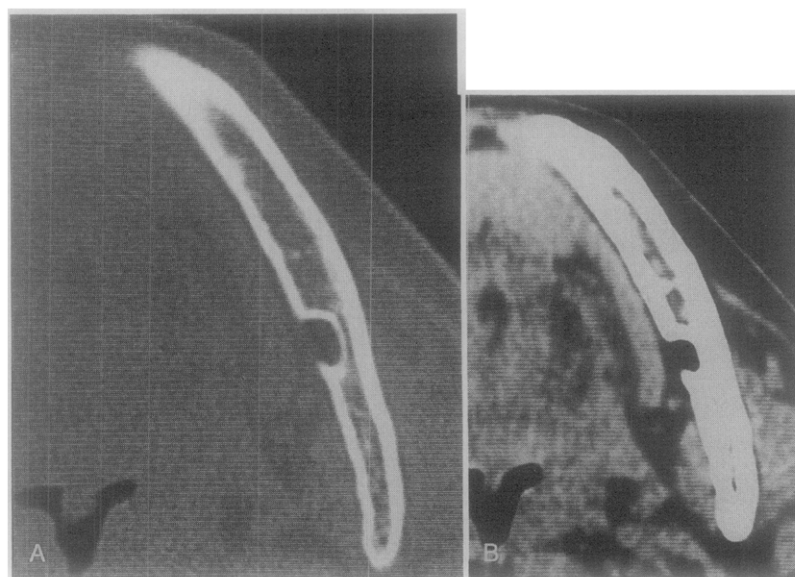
Axial CT images of case 3. A, Bottom of concavity does not reach buccal cortical plate. B, Soft tissue image clearly shows that concavity is occupied with only fat tissue density. CT value of content was -130 HU.
